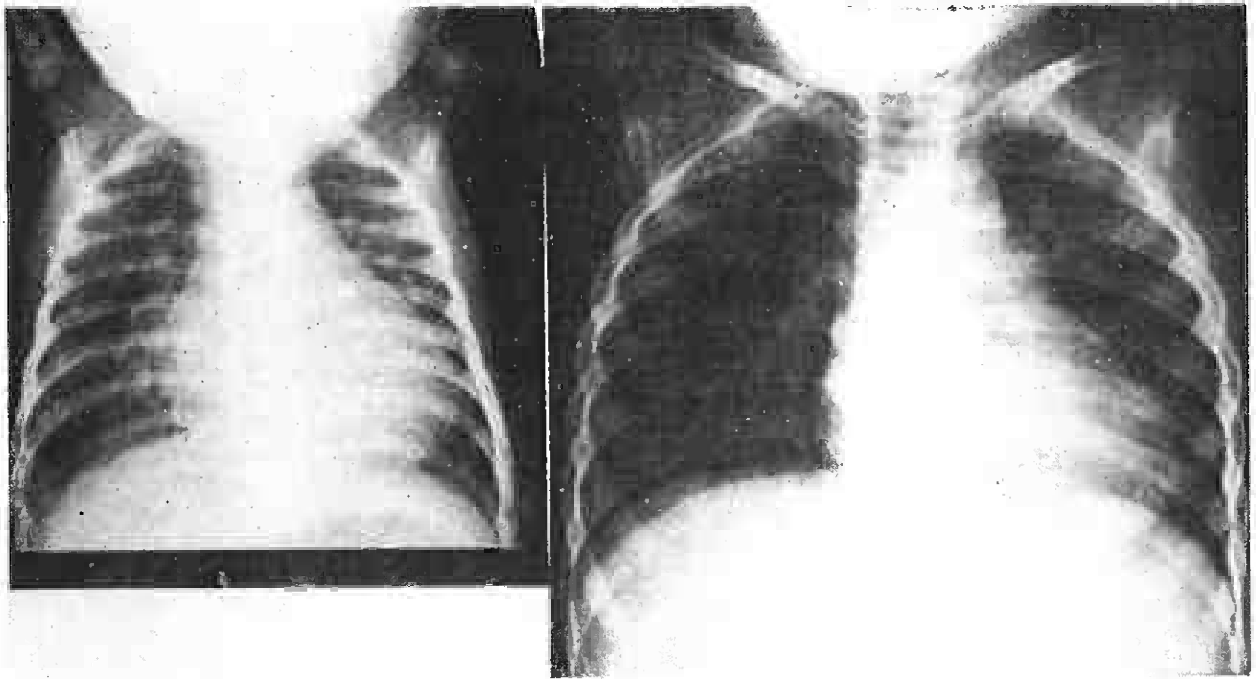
The chest X-ray on the left shows marked pulmonary plethora and that on the right, normal lung fields.
